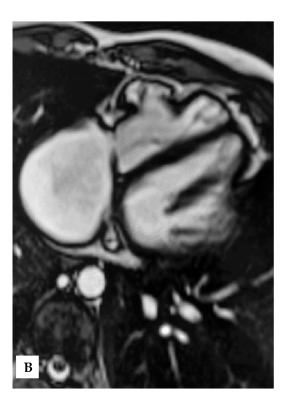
A,B: Cardiac MRI showing thickened pericardium(solid arrow) and RV free wall aneurysms(stars).
